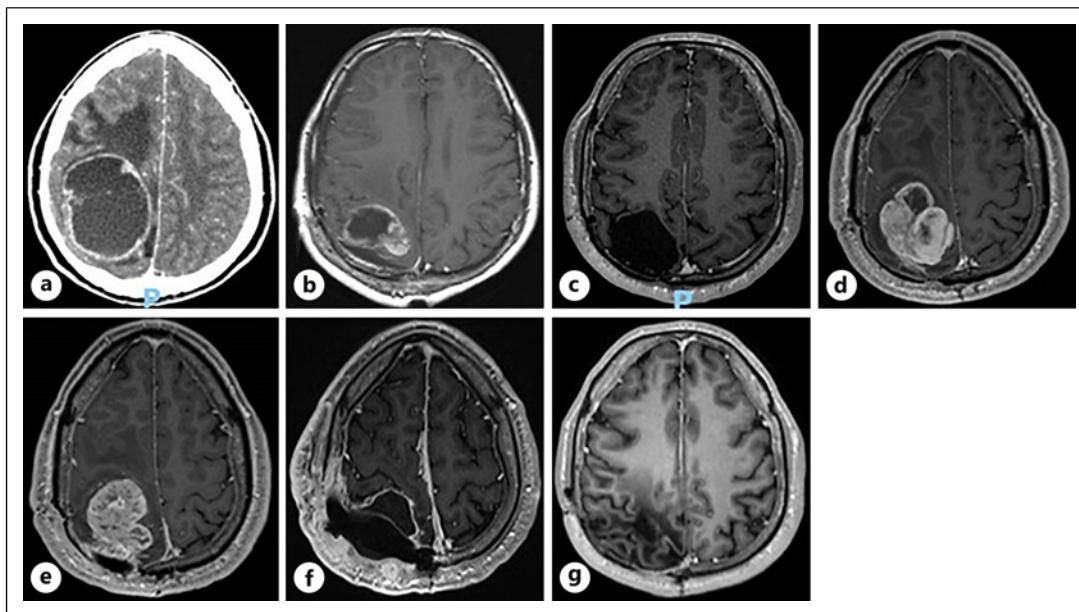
Radiological intracranial evolution. a CT scan at first presentation showing a cystic PXA. b MRI of the brain showing first recurrence of the PXA 6 months after initial surgical resection. c The patient was followed by MRI which showed no evidence of disease during 14 years after gross total resection. d MRI of the brain revealing a second recurrence after 20 years of progression free survival. e MRI of the brain showing a third recurrence 3 months after third surgical resection. f MRI of the brain showing a fourth recurrence with subcutaneous after fourth surgical resection and radiotherapy (2×20 Gy), accompanied by multiple extracranial metastases (the latter not visible on the depicted image). g MRI of the brain showing a complete intracranial response 2 months after initiation of BRAF/MEK inhibition therapy.
